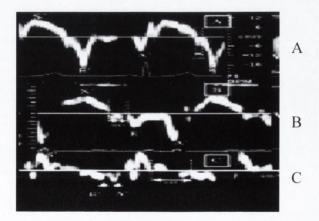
(A-C) Mitral annular pulsed-wave (PW) Doppler tissue imaging tracings in (A) a normal subject, (B) a patient with abnormal left ventricular (LV) relaxation, and (C) a patient with restrictive cardiomyopathy.
